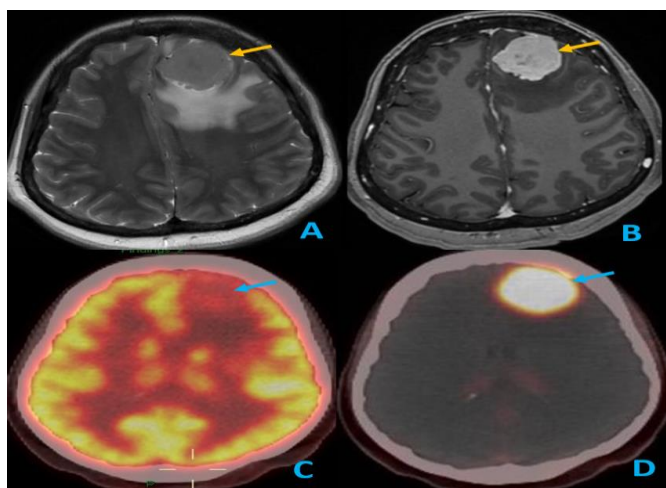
Space occupying left frontal lobe mass lesion; a) Axial T2W image shows a large intermediate signal intensity lobulated extraaxial soft tissue mass with perilesional vasogenic edema and mass effect b) corresponding axial T1W Fat suppressed sequence shows intense contrast enhancement c) ¹⁸F-FDG PET/CT scan do not show metabolic activity d) ⁶⁸Ga DOTATOC scan shows intense tracer uptake in the lesion suggestive of meningioma.
